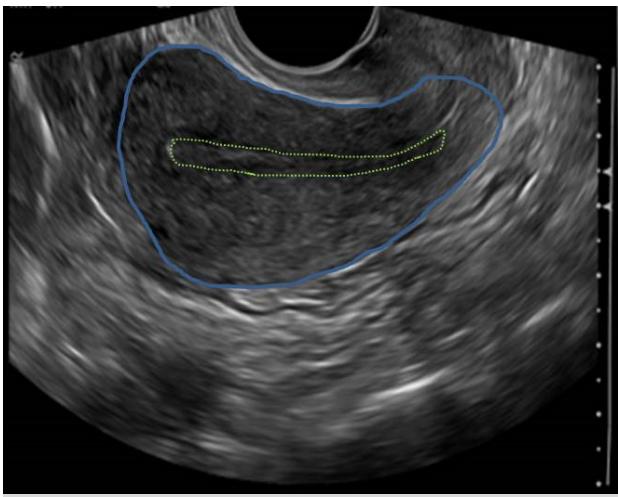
Transvaginal sonogram of uterus
